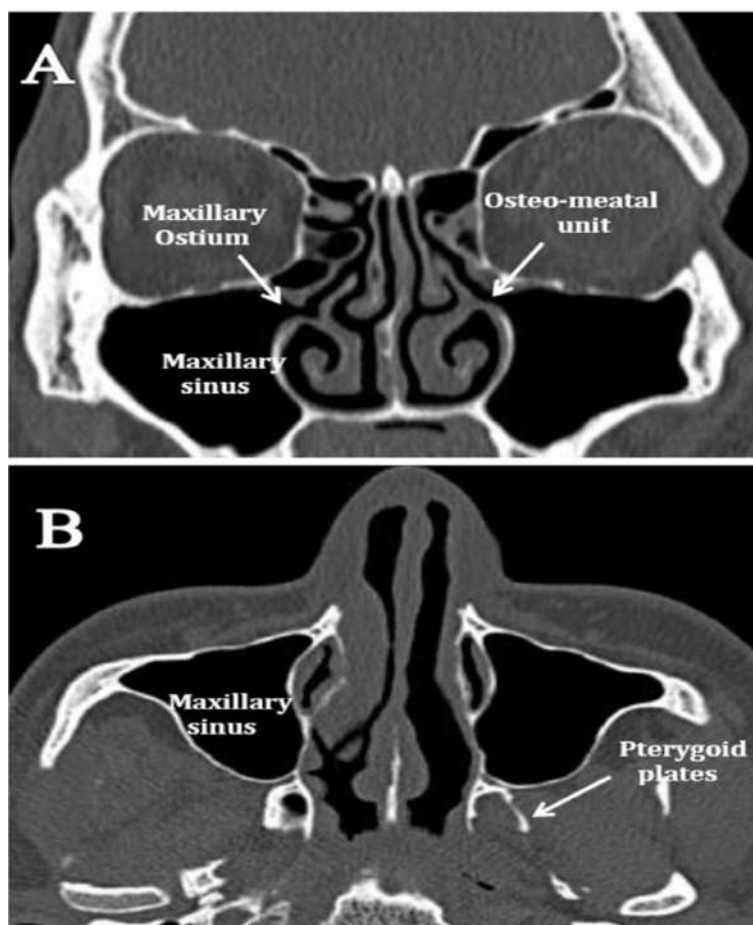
Computerised tomography, (A) Coronal CT image of normal maxillary sinus and ostium (B) Axial CT image of normal maxillary sinus Image courtesy : Abhay G. Kakade ; MVP Journal of Medical Sciences ⁴³
